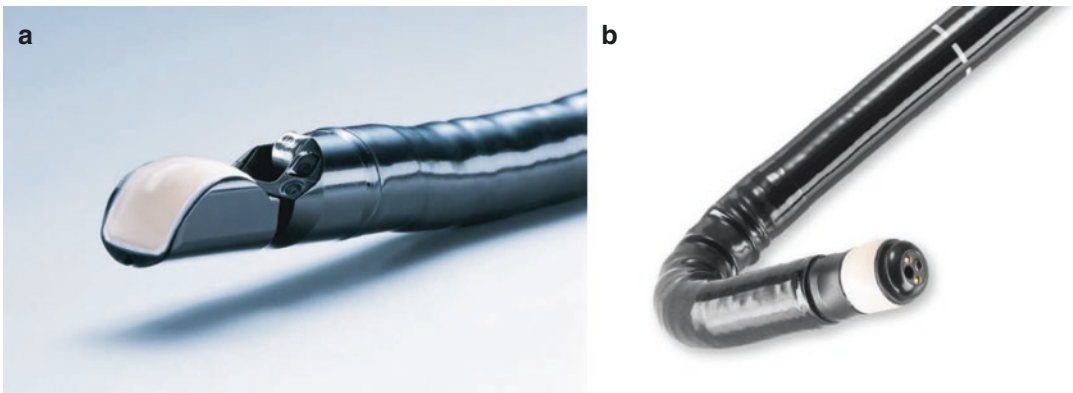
Pentax EG-3870UTK (a) ultrasound video endoscope utilizes a curved, linear-array ultrasound transducer that provides a large 120° field of view. The EG-3670URK (b) features a 360°, electronic, radial-array ultrasound transducer, which generates high-resolution
